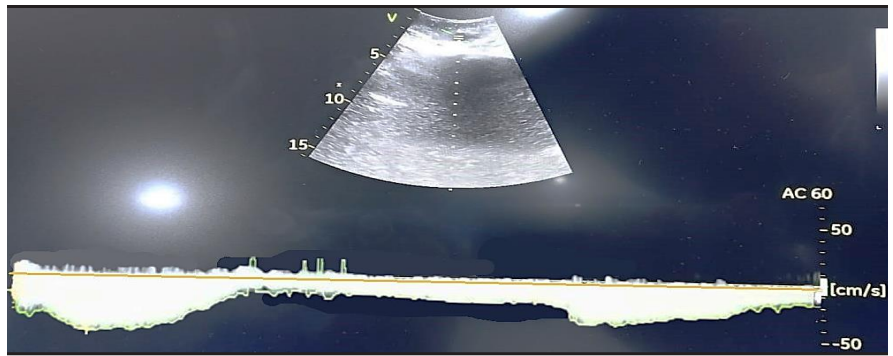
PW Doppler assessment of CFV waves in short axis view showing a normal venous waveform with an uninterrupted flow pattern with respiratory dynamicity (CFW = common femoral vein).
